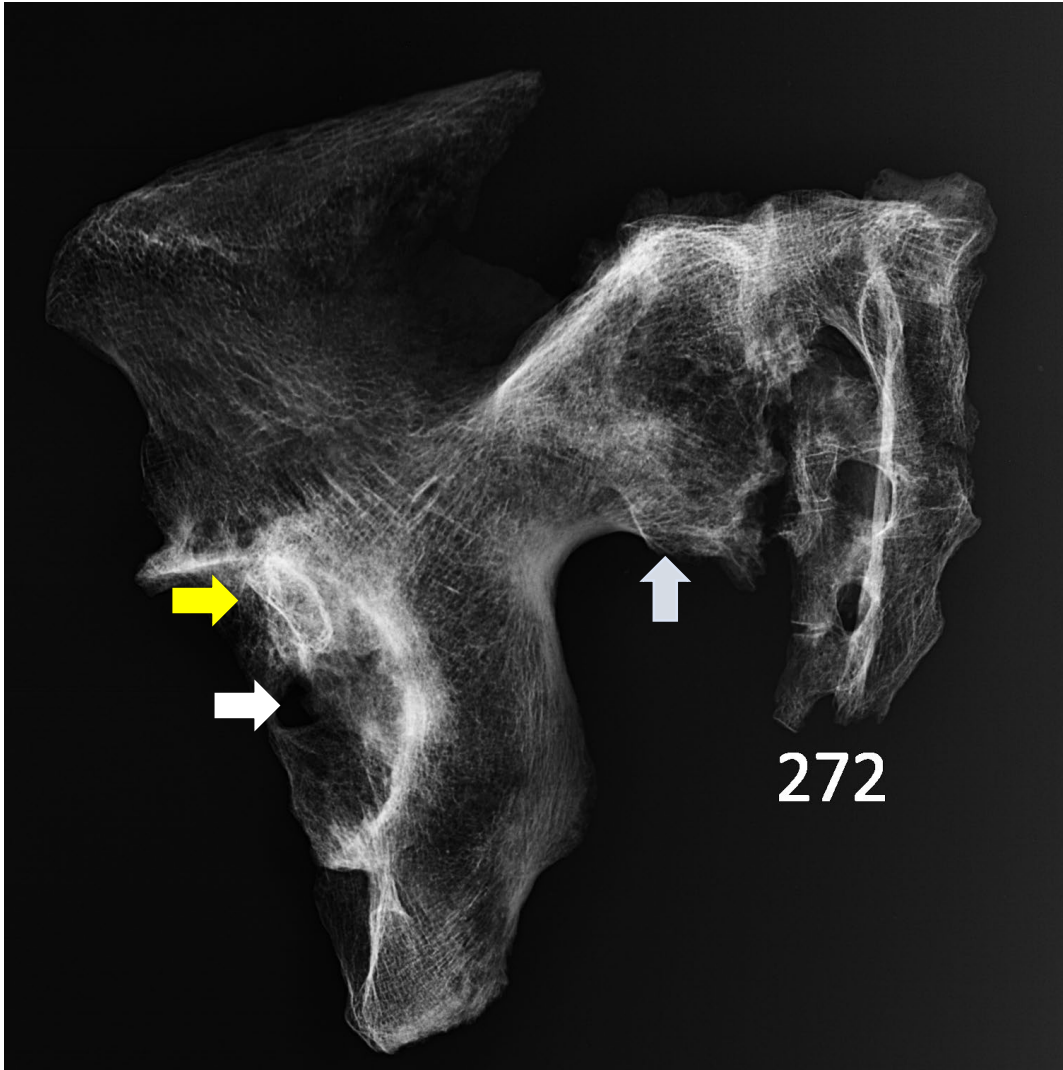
Radiograph of the pathology consistent with probable osteomyelitis. Osteolytic destruction (white arrow) is associated with significant marginal lipping of the acetabulum (yellow arrow). Note the sacroiliac ankylosis (light blue arrow). There are no clear signs of trauma. (AT-272, young adult male, Slab Grave culture). Image: author's own.
